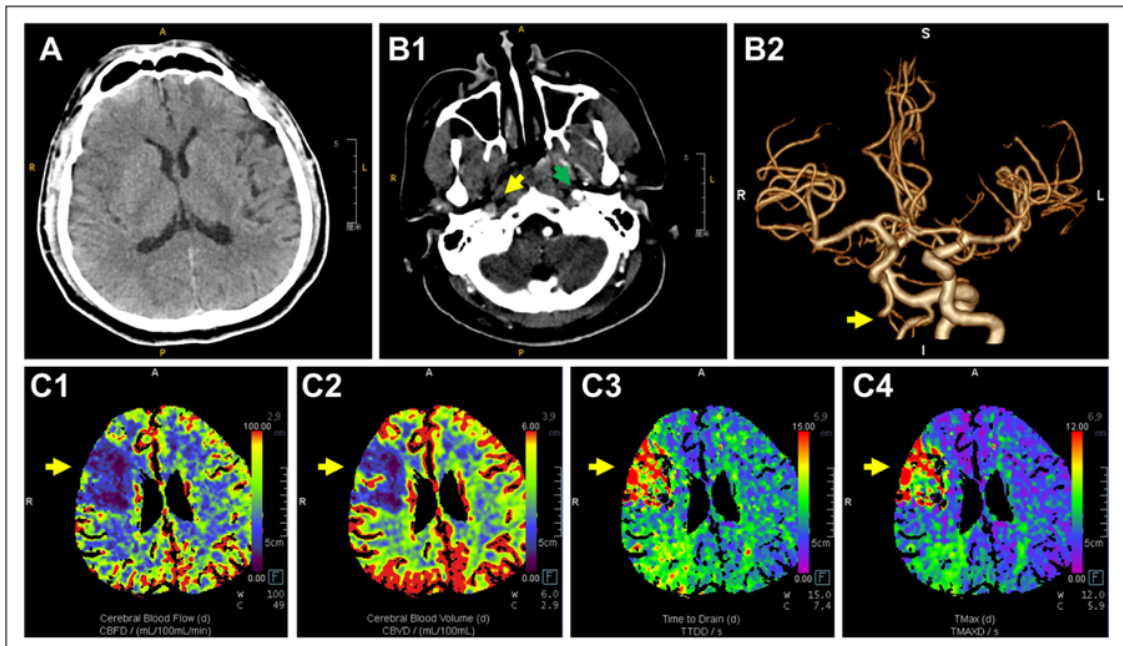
Imaging examination results obtained following the patient's admission to the stroke alert protocol. A. The non-contrast head CT scan revealed unremarkable morphology of both cerebral hemispheres and the brainstem. Additionally, there was a focal area of mild hypodensity adjacent to the right lateral ventricle. B1. The cross-sectional image of the cranial CTA showed non-visualization of the right internal carotid artery. B2. The 3D reconstruction of the cranial CTA suggested occlusion of the right internal carotid artery. C1-C4. The CTP demonstrated reduced cerebral blood flow (C1) and cerebral blood volume (C2), prolonged time to drain (C3), and extended time to peak (C4) in the right frontal and insular lobes.
